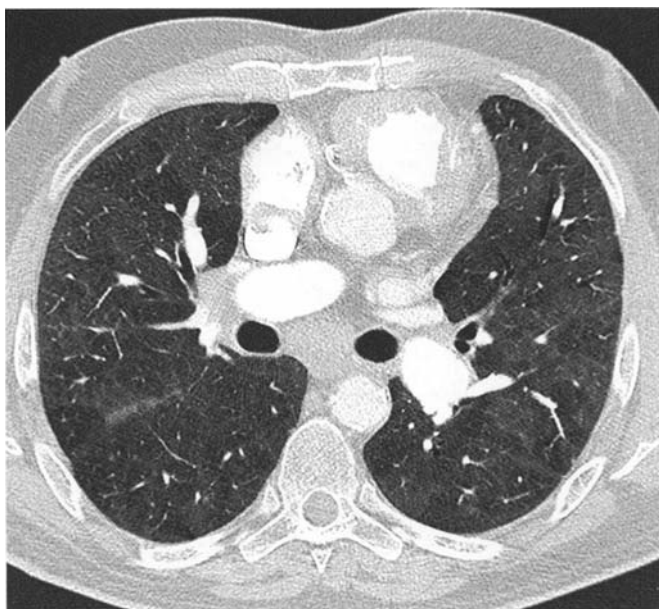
An HRCT of desquamative interstitial pneumonia shows widespread ground-glass opacification.
